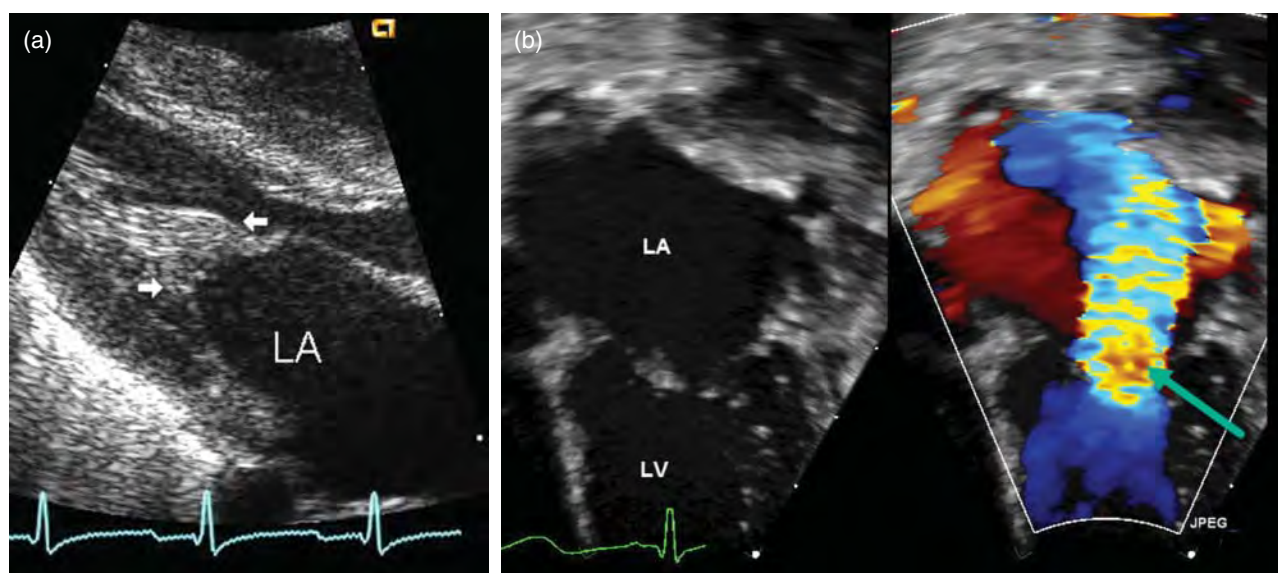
(a) Parasternal long-axis echocardiographic view in MV arcade showing direct insertion of valve leaflets into the papillary muscles through short or absent chordae (arrows). LA, left atrium. (b) Apical echocardiographic view in MV arcade showing a 2D image in the left and color flow Doppler demonstrating severe mitral regurgitation in the right.
